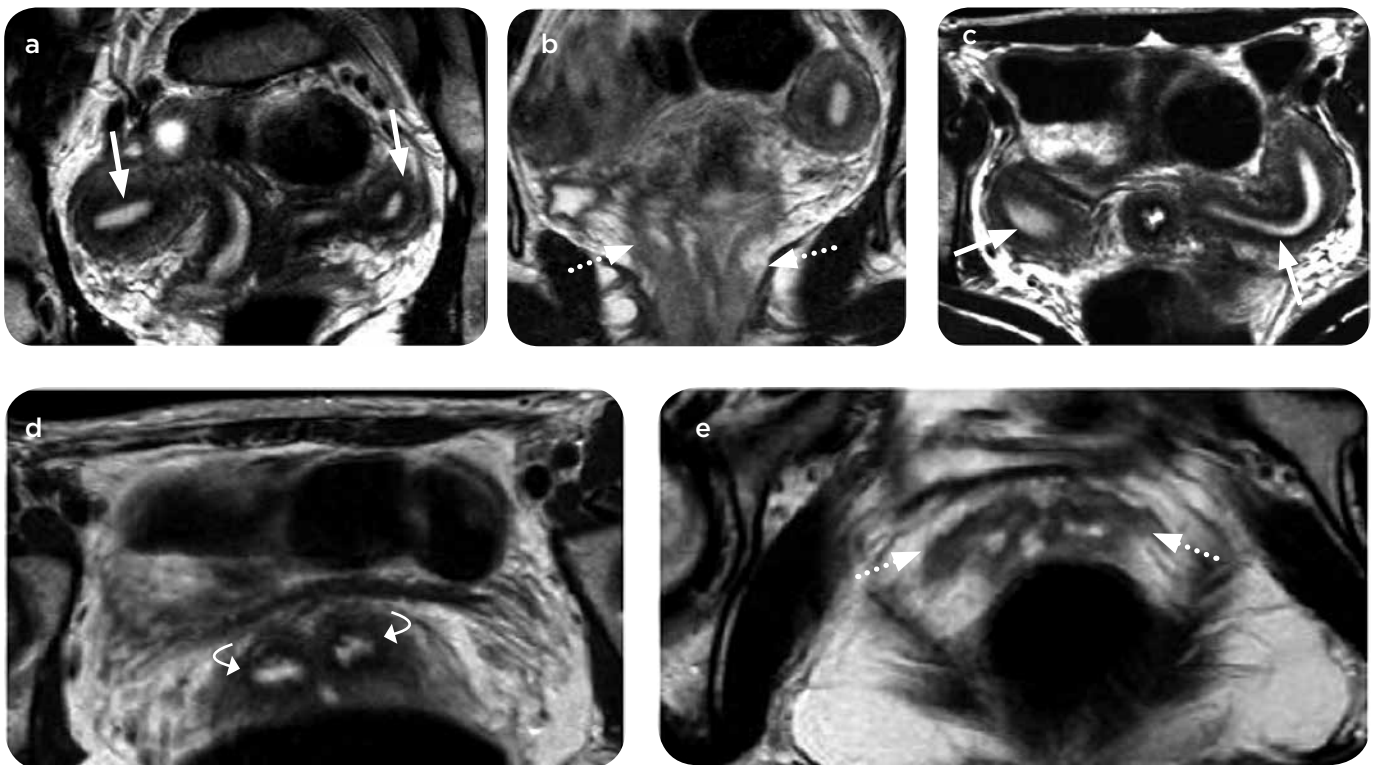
Uterus didelphys. a and c) Oblique coronal MRI TSE enhanced in T2. b, d and e) Axial TSE enhanced in T2. Two completely separated and divergent uterine cavities, with independent endometrial cavity (arrows in a and c). Two uterine necks (curved arrows in d) and two vaginas (dotted arrows on b and e).
